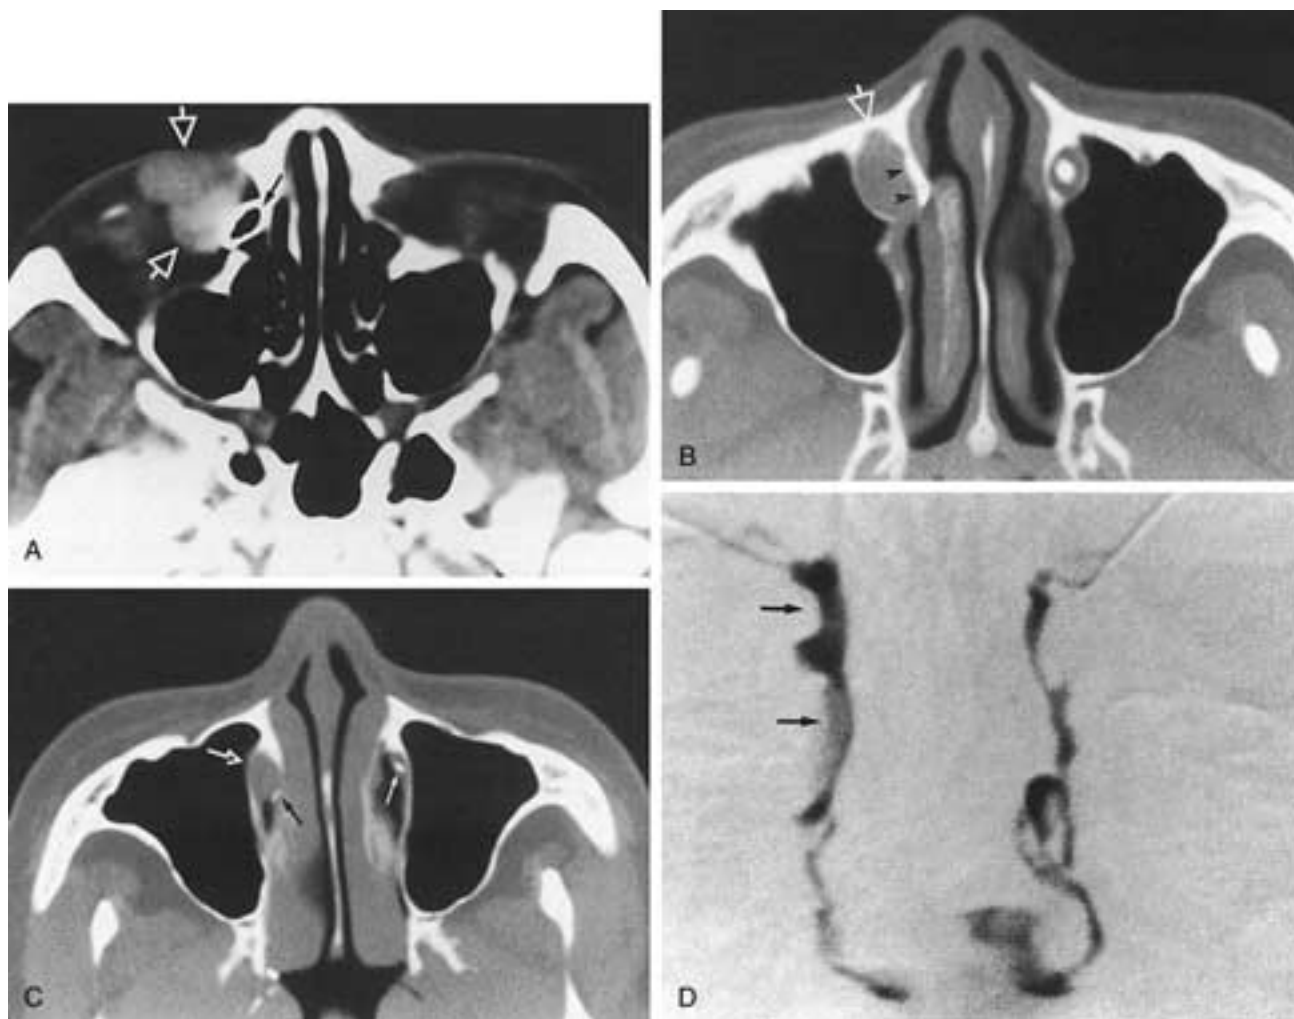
CT-DCG to identify the relationship between an inner canthus mass and the NLDS. A to D, Patient with a 2-year history of swelling of the right inner canthus. No epiphora. A to C, Axial CT-DCG scan from the superior to the inferior location. A, Large lobulated mass seen in the right inner canthus (*open arrow*) displacing the lacrimal sac (filled with contrast and seen as black because of density misregistration) (*solid arrow*) posteriorly within the nasolacrimal fossa. B, Enlarged right nasolacrimal canal (*open arrow*) with a contrast-filled nasolacrimal duct is compressed medially (*arrowheads*), resembling the bony wall of the canal. Normal left NLDS. C, At the level of the inferior meatus, normal termination of the left NLDS (*thin arrow*). Soft tissue on the right (*arrow*) displaces the contrast-filled nasolacrimal duct (*black arrow*) posteromedially. D, DCG. Prior to CT, only lateral indentation (*upper arrow*) of the dilated lacrimal sac was discussed, with less attention to the medial displacement of the nasolacrimal duct (*lower arrow*). Pathology: benign lacrimal sac cyst (from the wall of the lacrimal sac).
